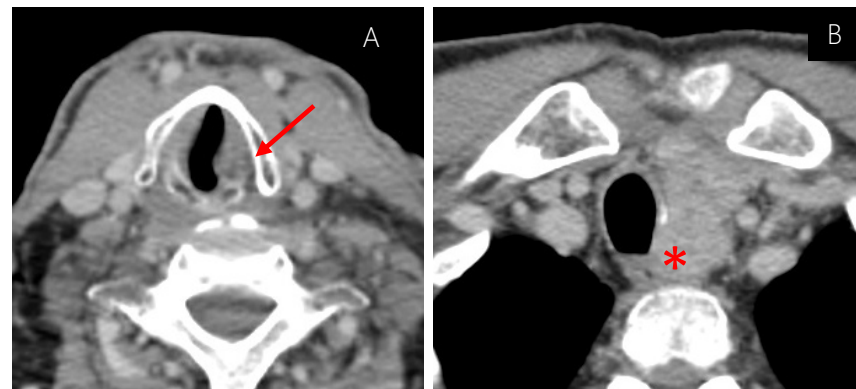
Contrast enhanced CT in a patient presenting with hoarseness shows a fixed and adducted left vocal (red arrow) due to an infiltrative mass extending into the left tracheo-oesophageal groove (asterix), confirmed medullary thyroid carcinoma.
